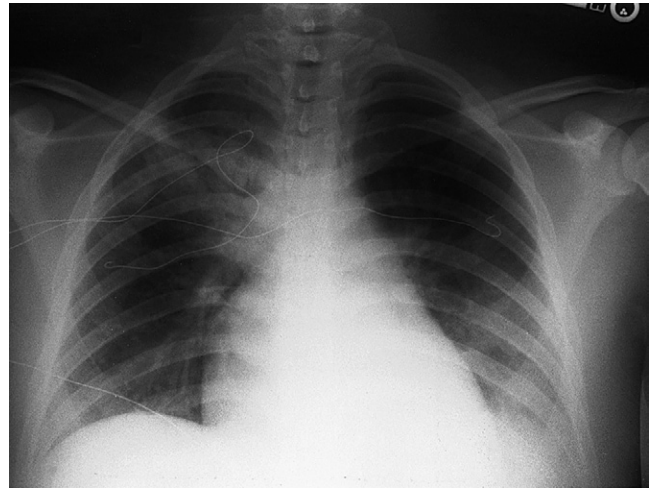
Portable chest radiograph of a 16-year-old female patient with SLE. Lupus pneumonitis is reflected by infiltrate in the right upper lobe and bilateral diffuse interstitial changes. Pleural fluid suggested by haziness over the left lower lobe, as well as blunted left costophrenic angle (not shown), was confirmed by bilateral decubitus films.
